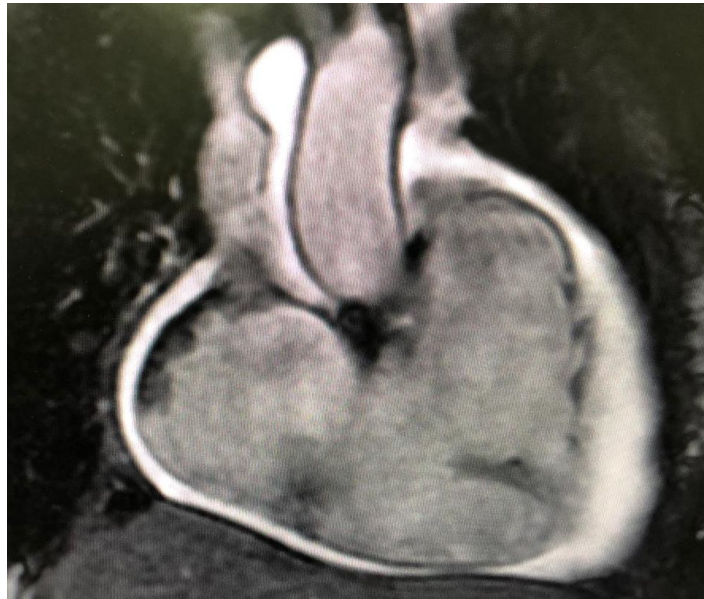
Cardiac MRI: T2 sequence: Hypertrophy of the right ventricle with multiple aneurysms of its free wall, presence of medium pericardial effusion.
